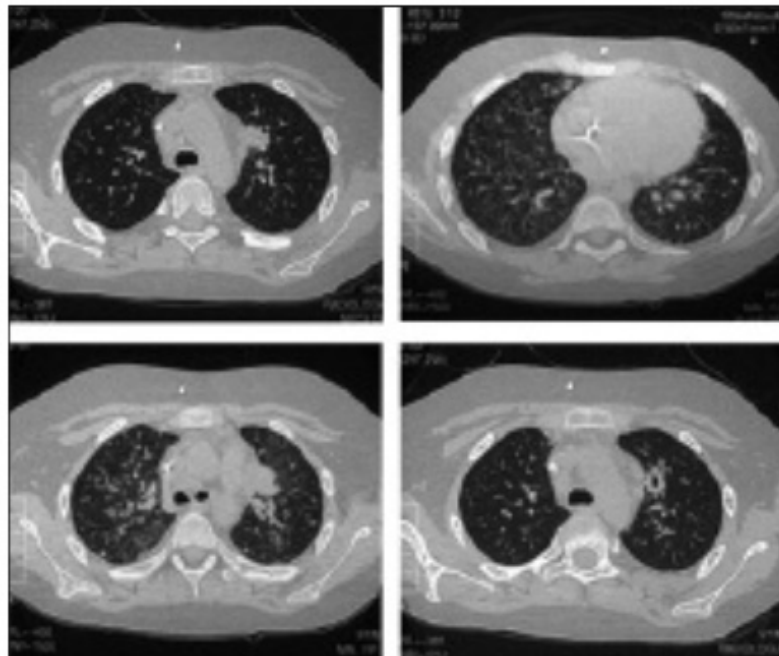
Chest CT scan shows the persistence of the diffuse reticulo-nodular parenchymal pattern, with a left paracardiac infiltrate: its hypodense core is suggestive for a cavitation process.
